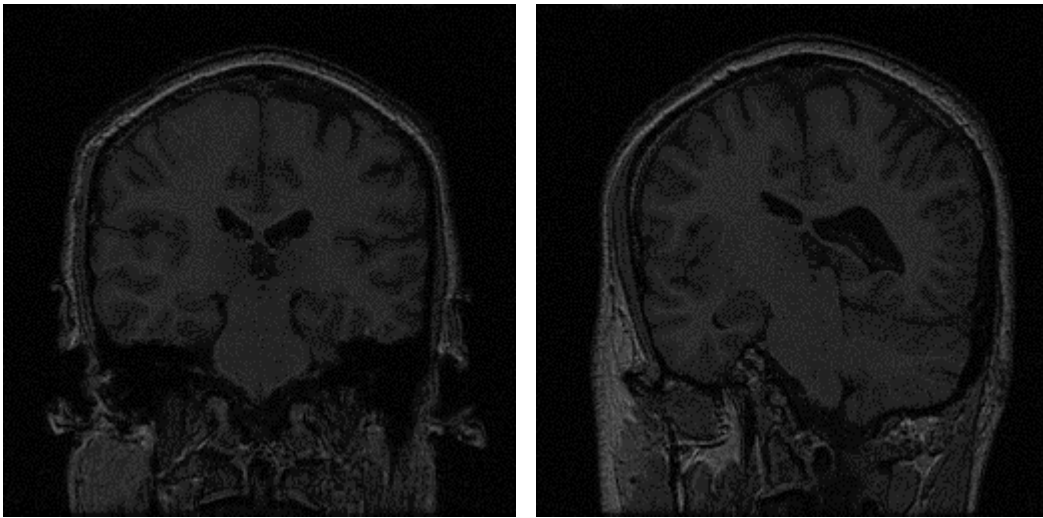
Slice 56 of the MRI acquisitions used for the study: straight (left) and rotated(right). Note the significant rotation of the right image.
